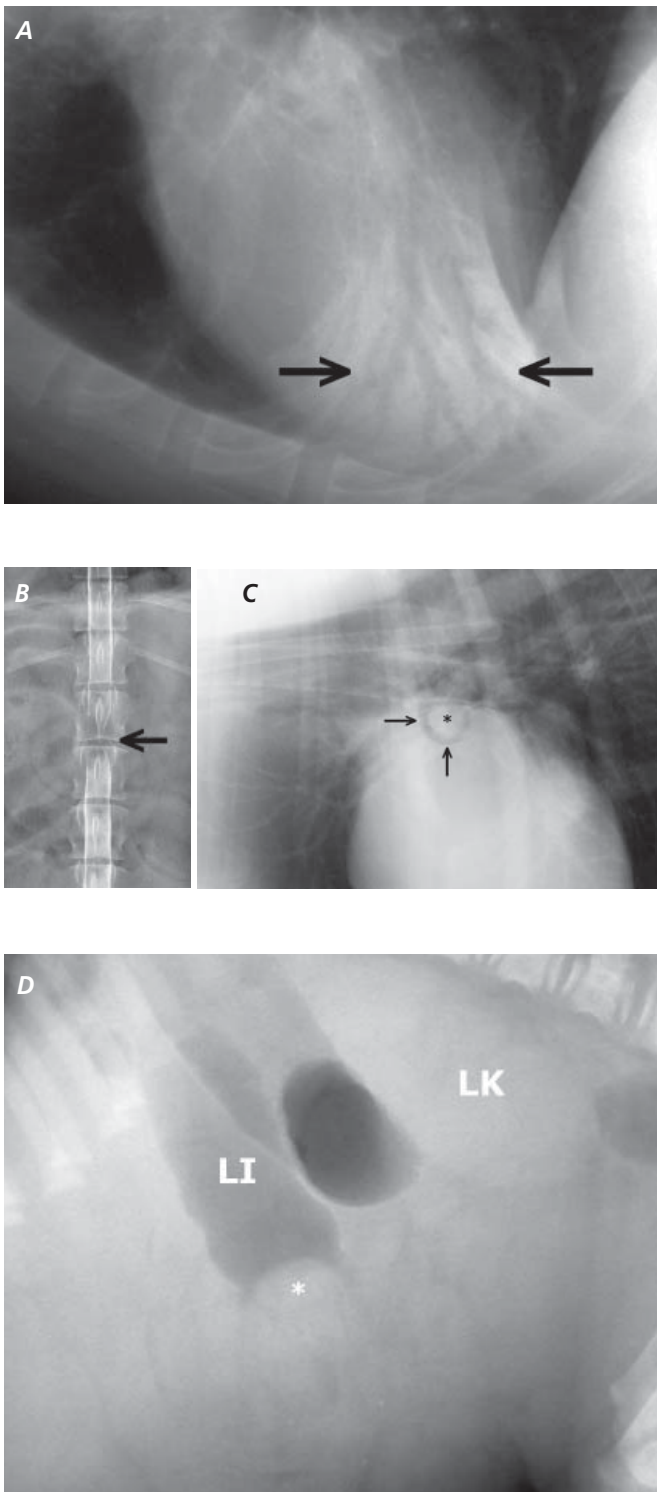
Examples of radiographic signs.
